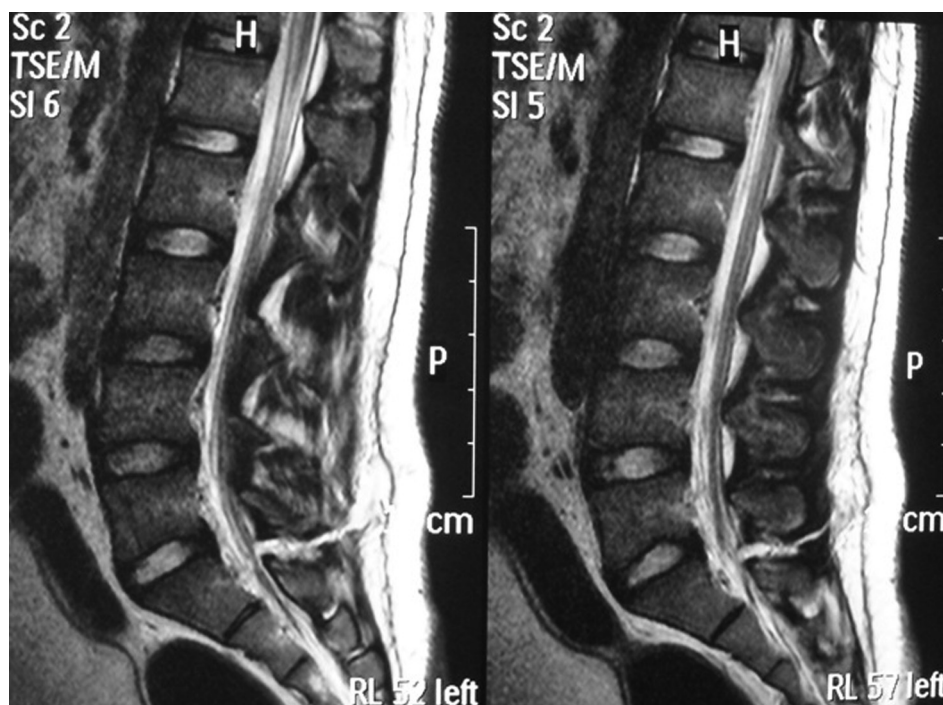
Sagittal T-2 weighting MR image shows knife track extending from skin to subarachnoid space.
